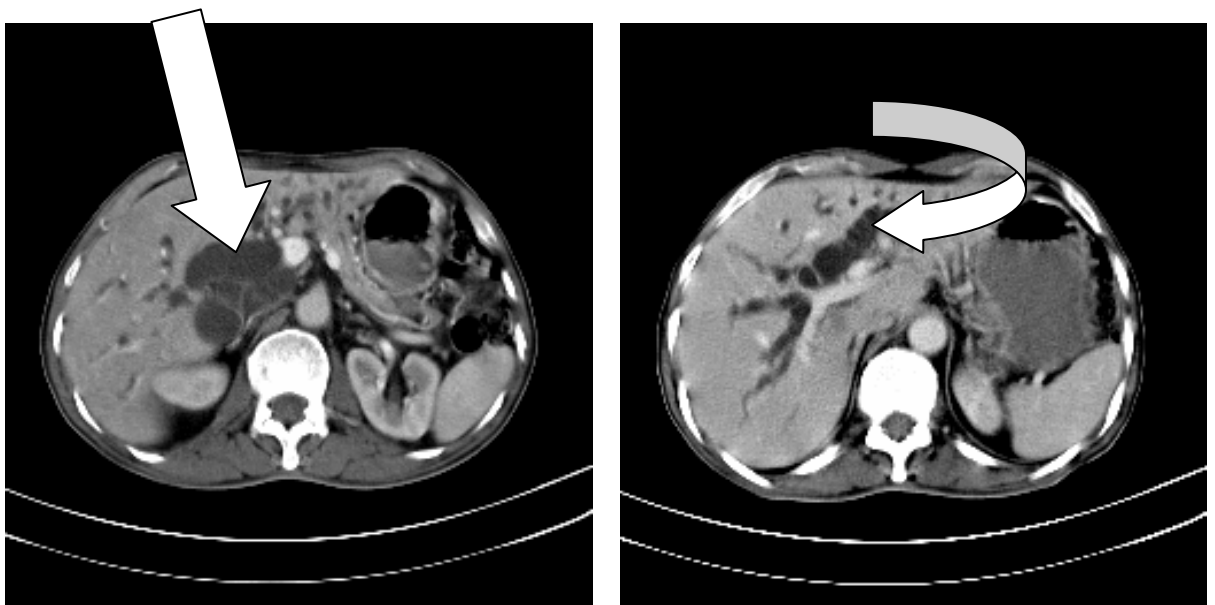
FIGURE # 11 : CONTRAST ENHANCED CT ABDOMEN AXIAL SECTION OF VENOUS PHASE SHOWING NECROTIC COMPONENTS IN PANCREATIC HEAD AND BODY (ARROW) WITH LOSS OF PERIPANCREATIC FAT PLANES (CURVED ARROW).
